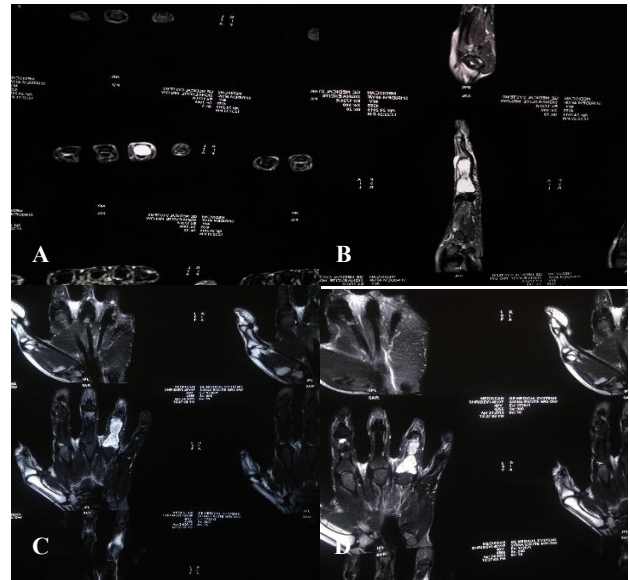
(A-D): MRI images of the lesion demonstrating an iso to hyper intense lesion on T2 and hyperintense lesion on STIR sequences. There were few T2 hypointense signals seen within the lesion suggestive of stippled calcification.
